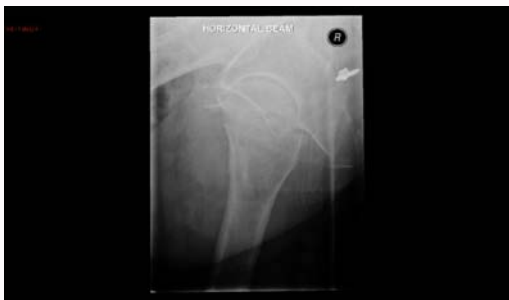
Lateral radiograph showing displaced right intra-capsular NOF fracture.
